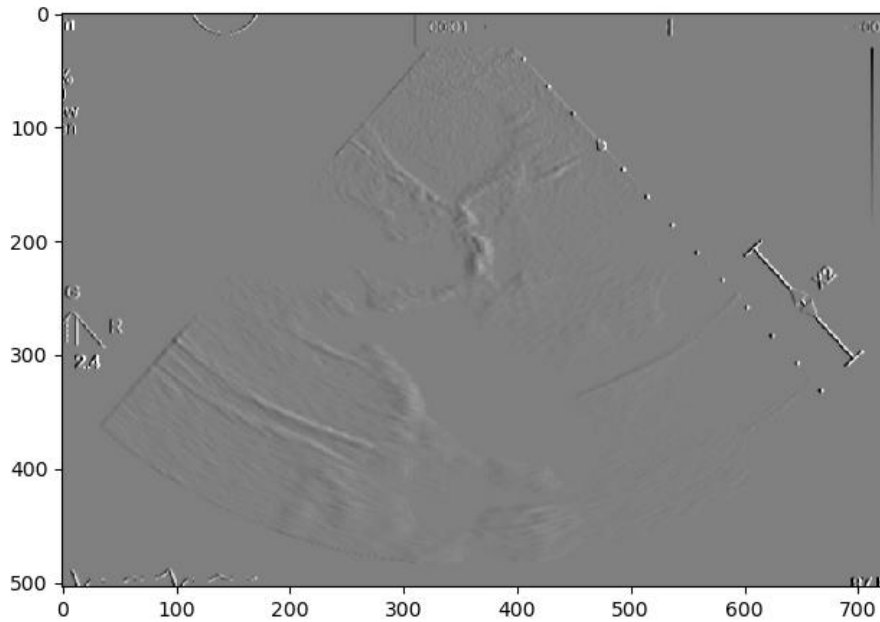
Echocardiography with Edge Detection
